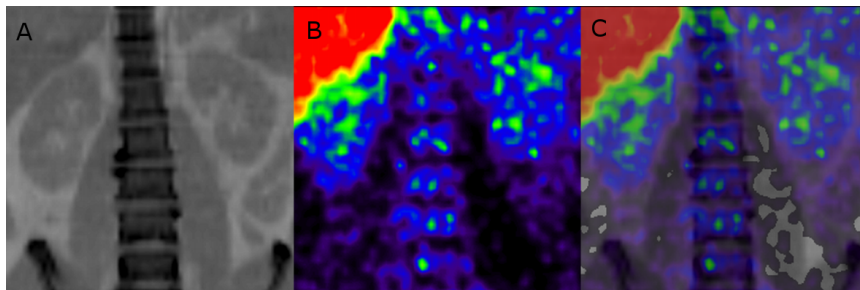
Typical example of coronal slices of CT (A), PET (B), and PET/CT (C).
